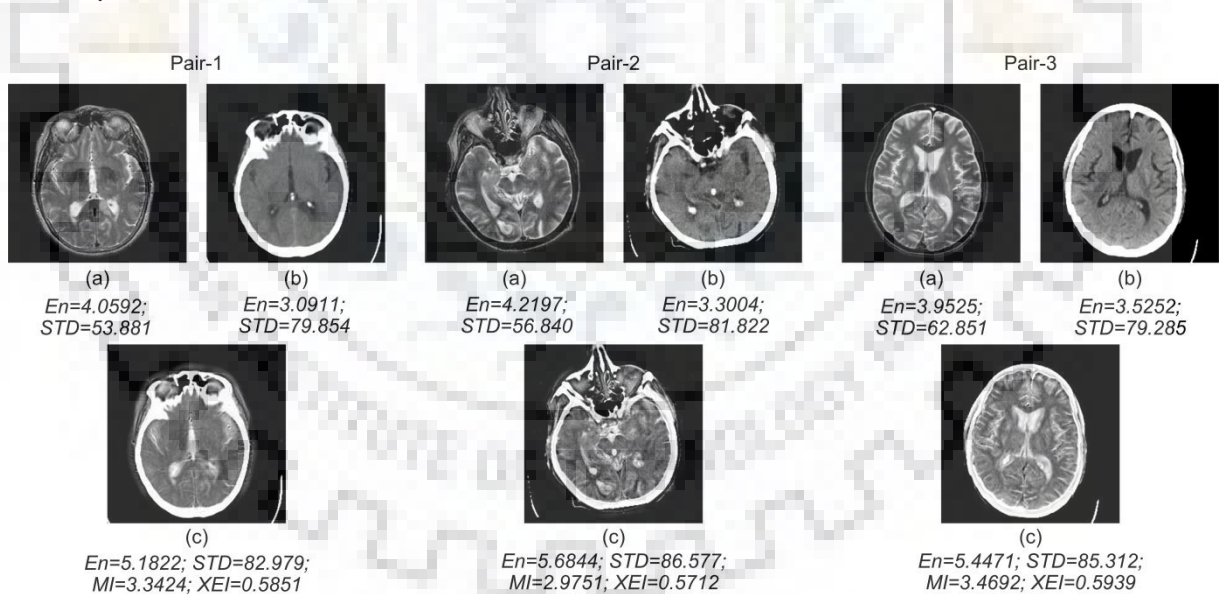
(a) Source MR image (b) Source CT Image (c) Image fused by the proposed SDL-MIF method
